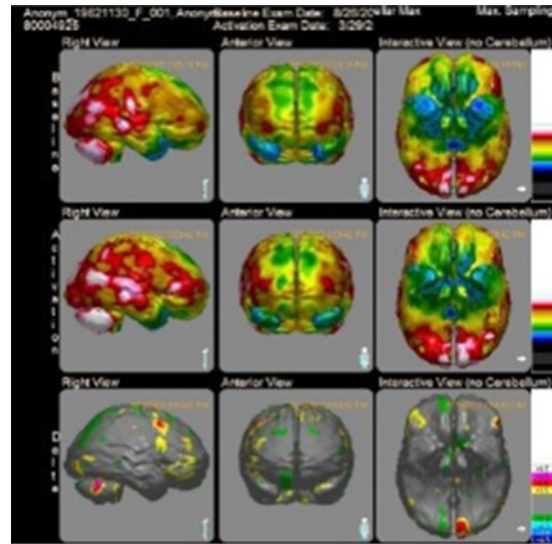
Case #2 SPECT images (upper row – before HBOT; Middle row- after HBOT; Lower row – Delta change).
